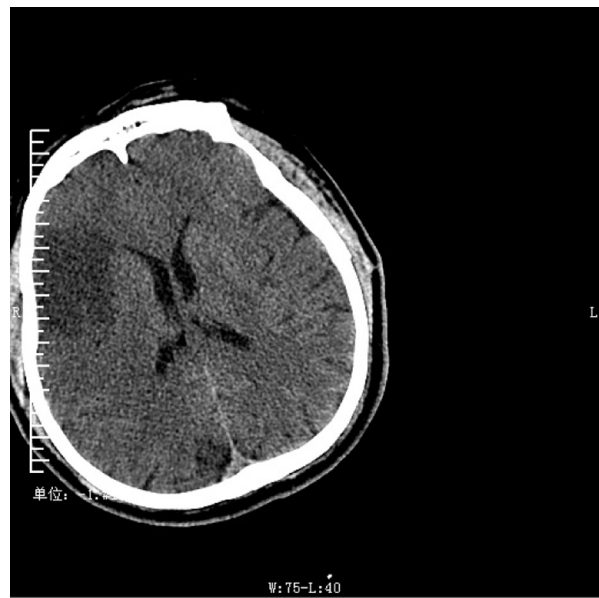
Cranial computed tomography scans 15 hours after intravenous thrombolysis.
